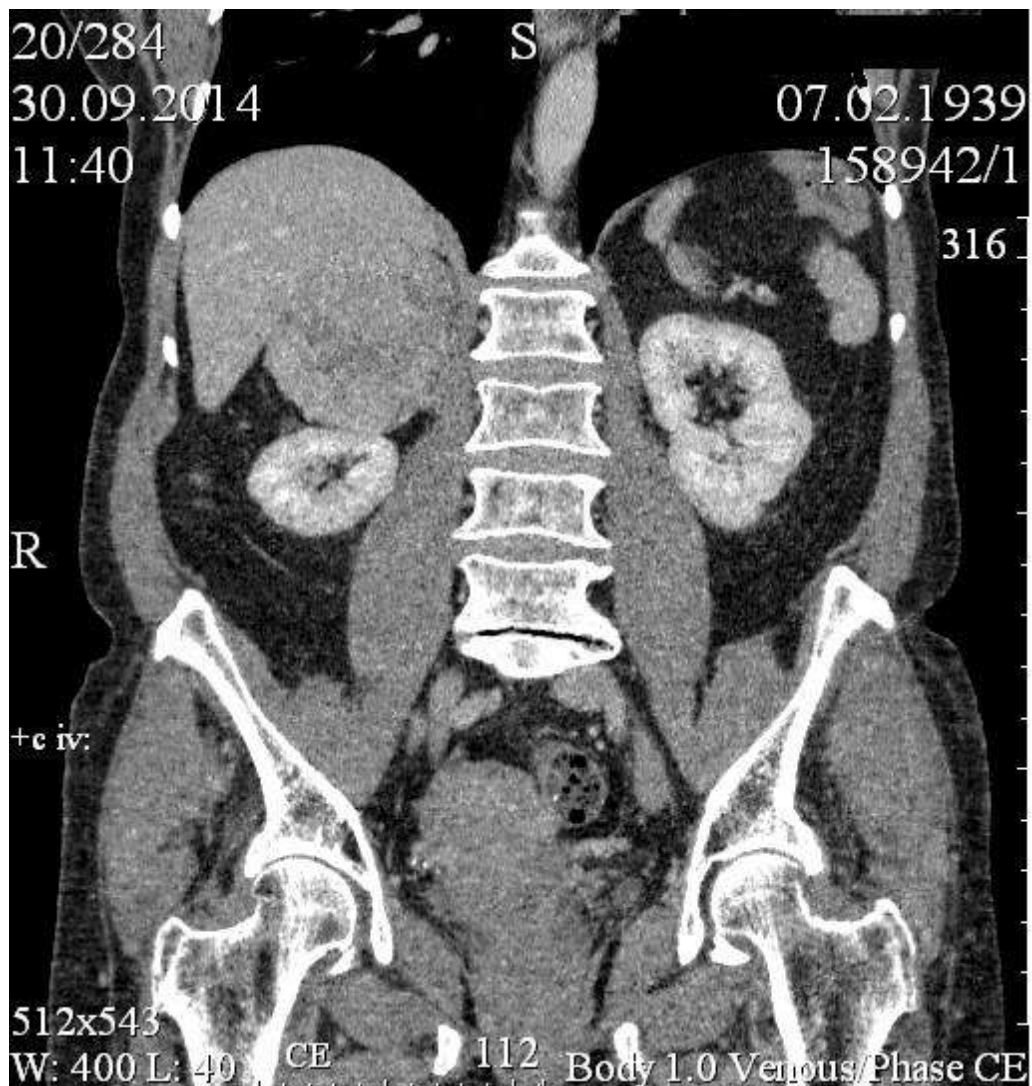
Carcinoma of the right adrenal gland. Computed tomography, venous phase of the study.
